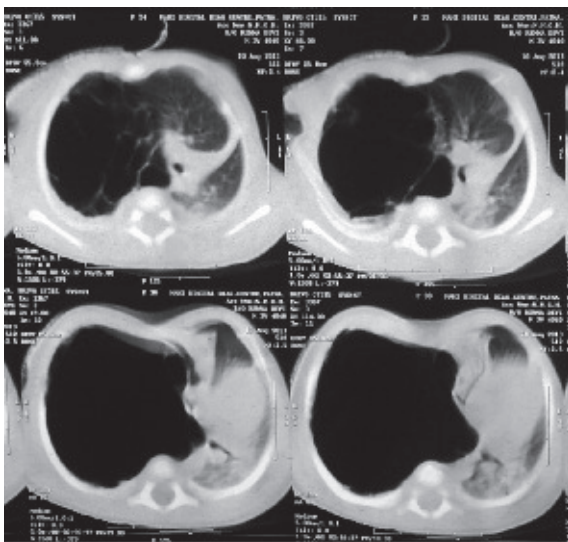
CT chest of the child
